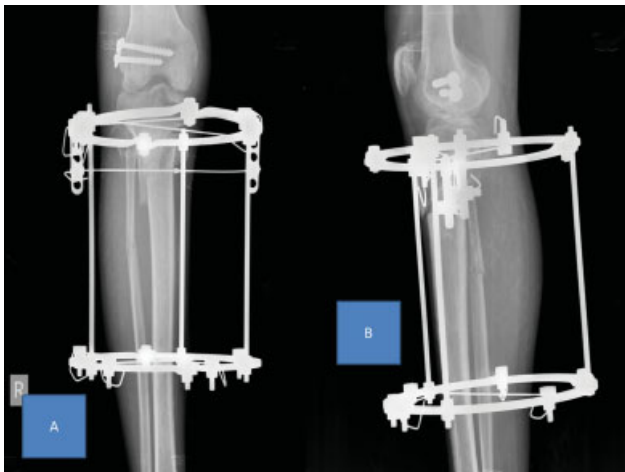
and 3B Anteroposterior and lateral radiographs of Patient 9 in the immediate postoperative period with ring fixation.
